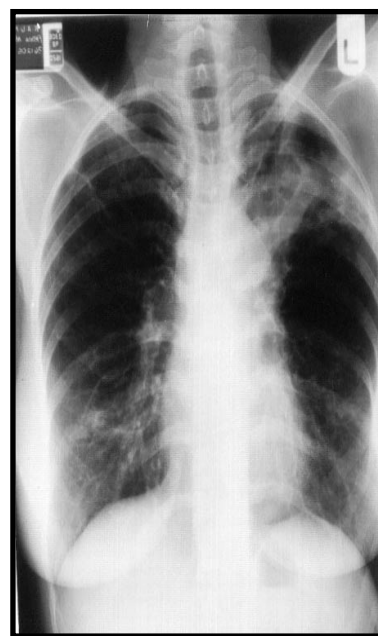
Patient 1 - Chest radiograph showed ill defined opacity with irregular thickened wall cavity affecting left upper zone. There is right apical infiltration and multiple different sized and shaped cavities on both lung fields.
